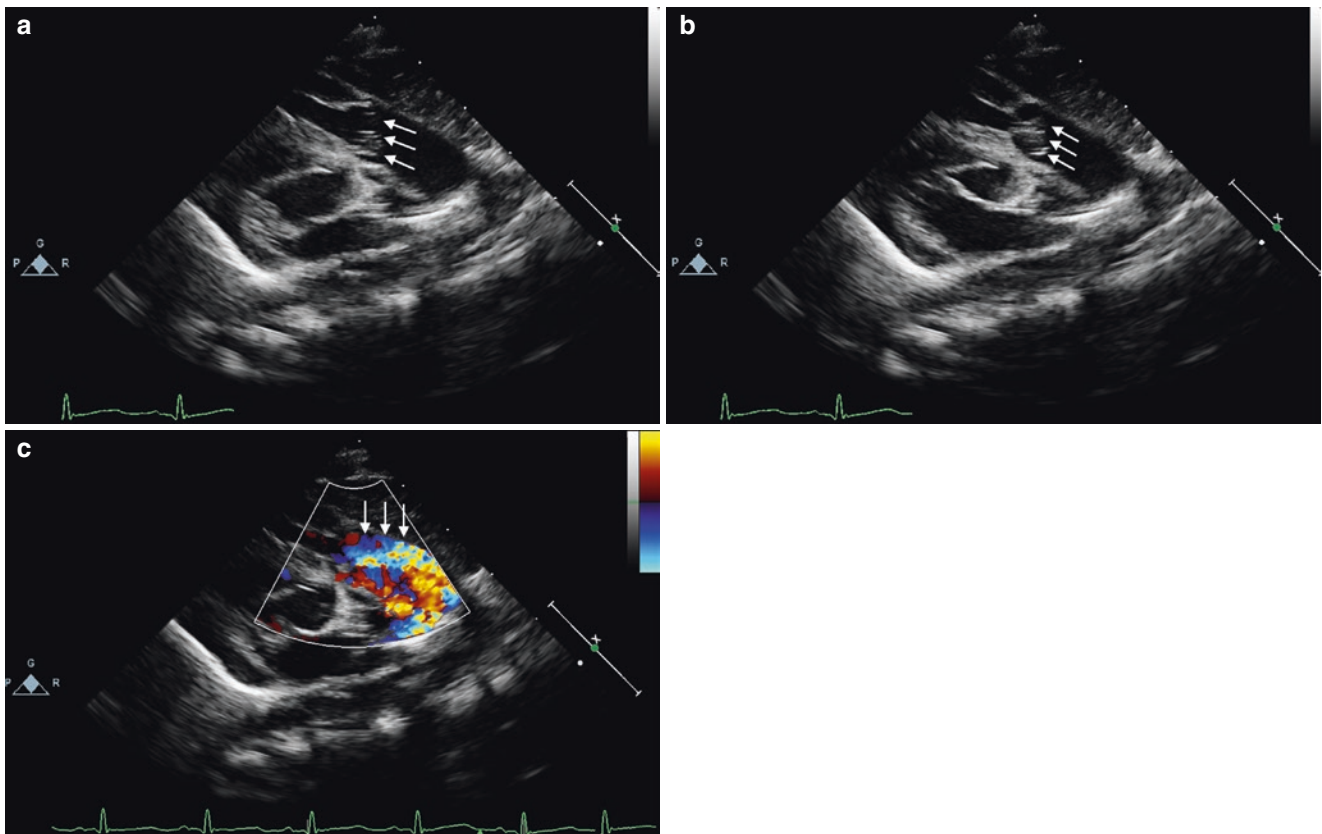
Apical four-chamber view in a neonate with critical pulmonary stenosis with significant apical hypertrophy (arrows) of the right ventricle (a). The diastolic frame shows bulging (arrows) of the atrial septum from right to left (b). Severe tricuspid regurgitation is displayed
